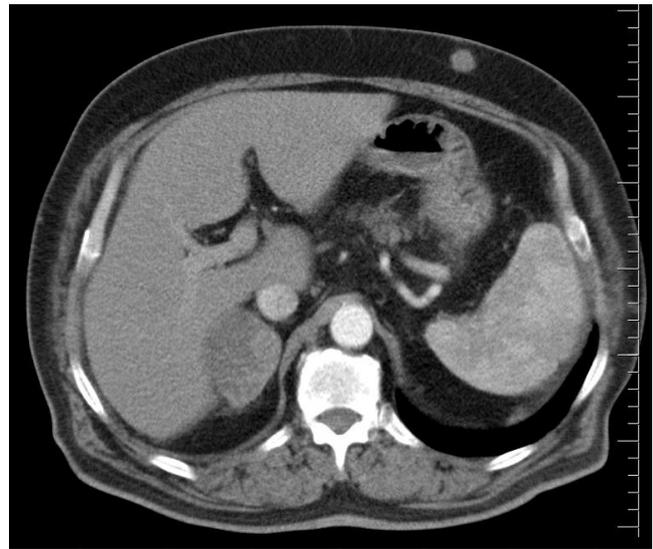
CT section of the subcutaneous nodule at the intersection of the right 6th intercostal space with the mid-axillary line with dimensions of 1.5x1 cm.
